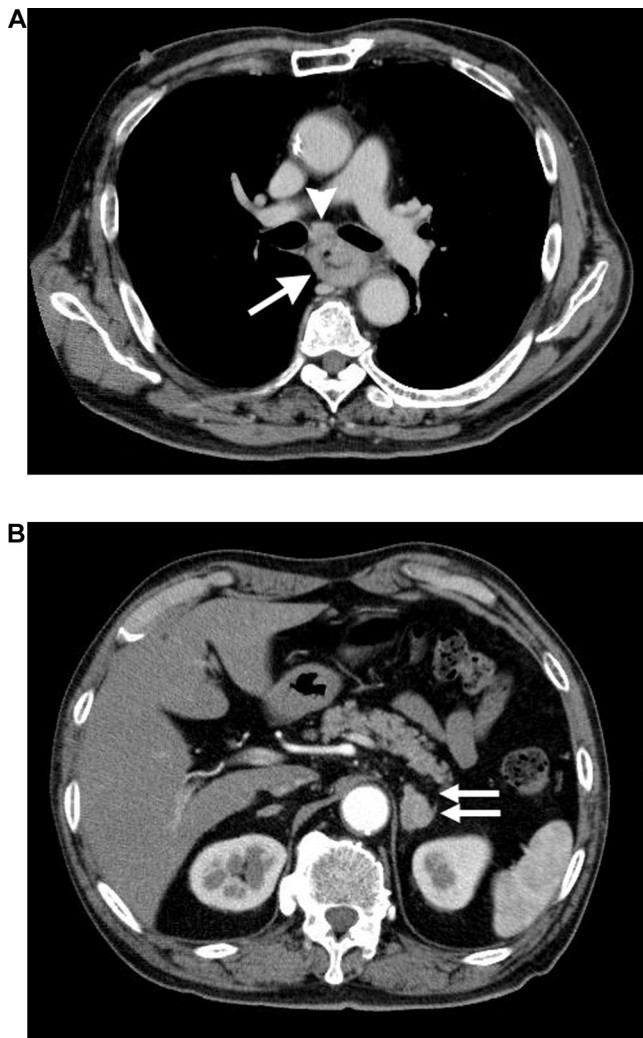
(A,B) Computed tomography scan revealed an esophageal tumor in the upper to middle thoracic esophagus (arrow) and enlarged subcarinal lymph nodes (arrow head) (1A). The left adrenal gland was enlarged (double arrows), suspected to contain a metastasis from the primary esophageal cancer (1B).
